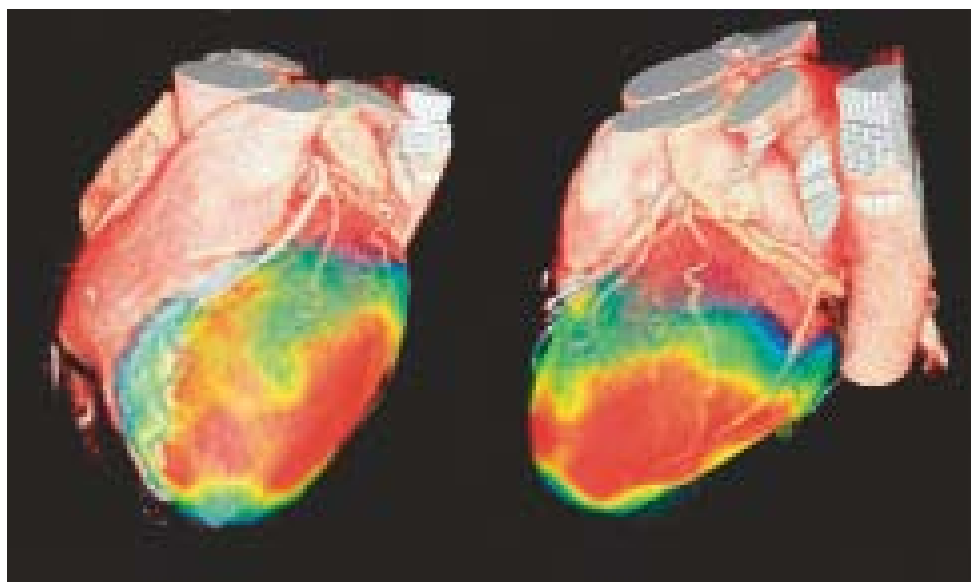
Integrated imaging allows comprehensive evaluation of coronary anatomy and perfusion. This stress myocardial perfusion imaging by SPECT is fused to a 64-slice CT. No abnormality is shown (courtesy by Prof. Dr. Philipp Kaufmann, University Hospital Zürich).
